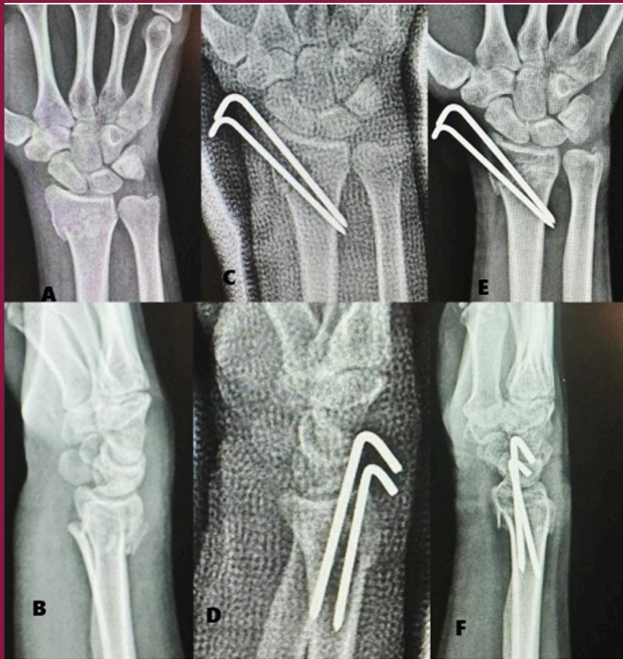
A 27-year-old female patient. A/B: Preoperative, C/D: After 2 weeks of operation, E/F: After 6 weeks of operation Pa and Lateral wrist X-ray
